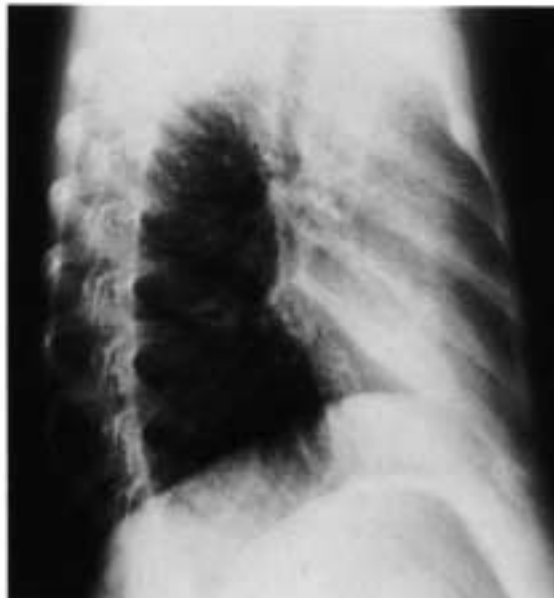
Chest radiograph on admission. a) posterioranterior view; b) lateral view.
